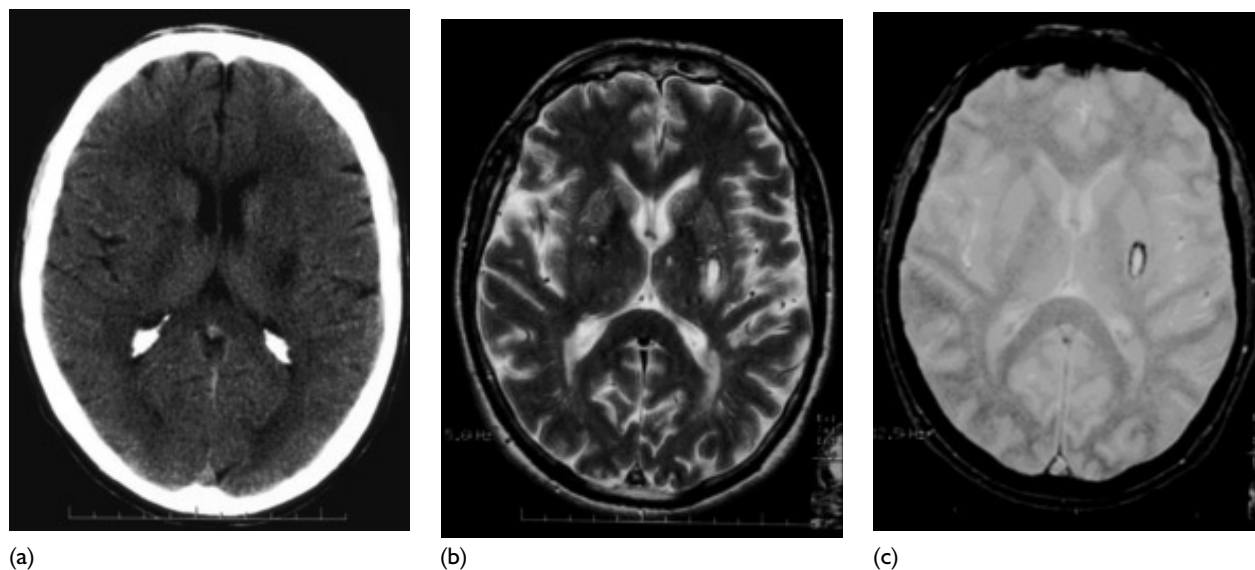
A 60-year-old man with right hemiparesis and right facial numbness, with residual reduced fine finger movements. (a) CT scan; (b) T2-weighted MR scan; (c) GRE MR scan. Scans were taken 21 days after the onset of symptoms.
